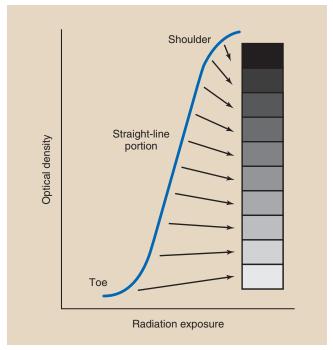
The characteristic curve of a radiographic screen-film image receptor is the graphic relationship between optical density (OD) and radiation exposure.
